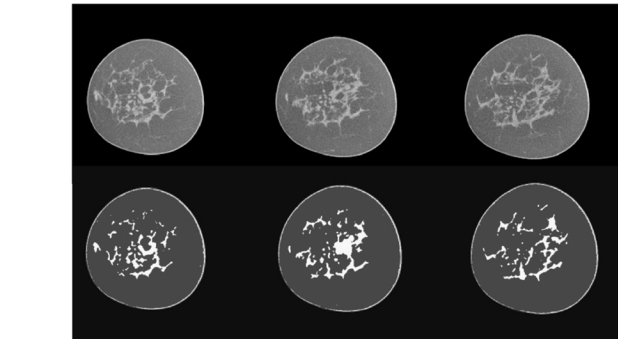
Selected original and segmented images from breast CT scan data for a typical breast. (a) Upper panel: mid-breast image slices. (b) Lower panel: same three slices as upper panel after classification.
